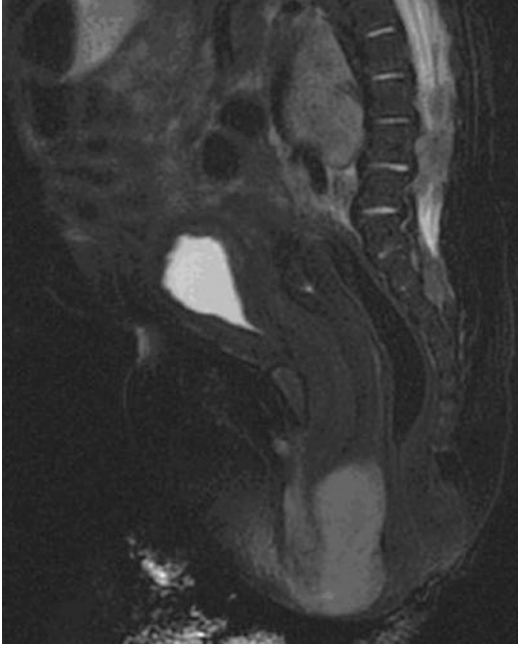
MRI Sagittal T2 image demonstrates bladder, uterus and rectum
